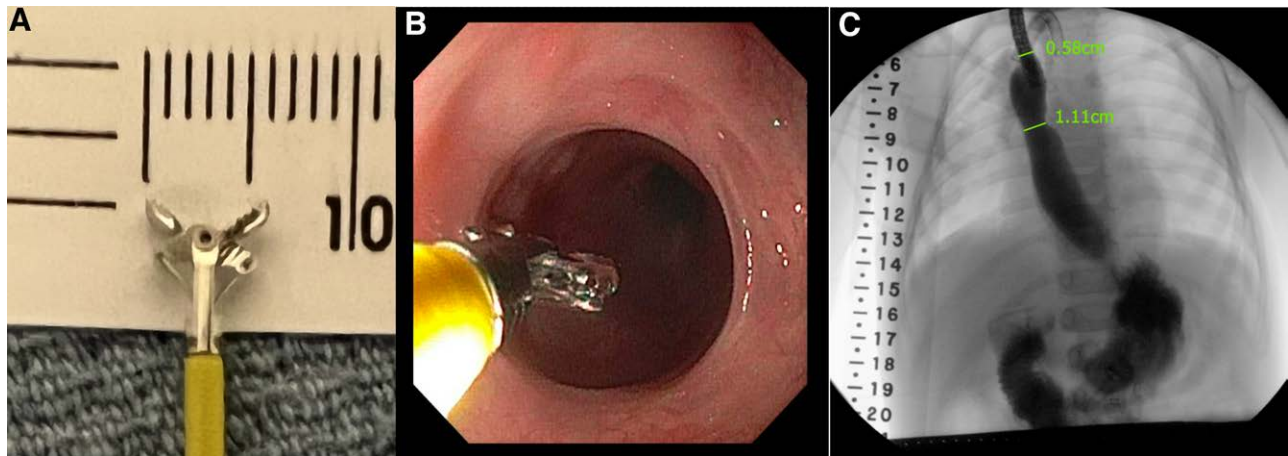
(A) Biopsy forceps are of known dimensions (pictured: approximately 6 mm wide for open yellow pediatric forceps; 7 mm wide for open orange standard capacity forceps). (B) The forceps are introduced into the field of view at the level of the esophageal stricture, permitting visual estimation of the size of the stricture diameter (pictured: approximately double the width of the open pediatric biopsy forceps, or 12 mm). (C). Intraoperative esophagram for patient pictured in (B). The radiographic ruler is calibrated to the known dimensions of the endoscope (pictured: Olympus XP endoscope with diameter 5.8 mm). The stricture is then measured with the calibrated software ruler (1.11 cm).
